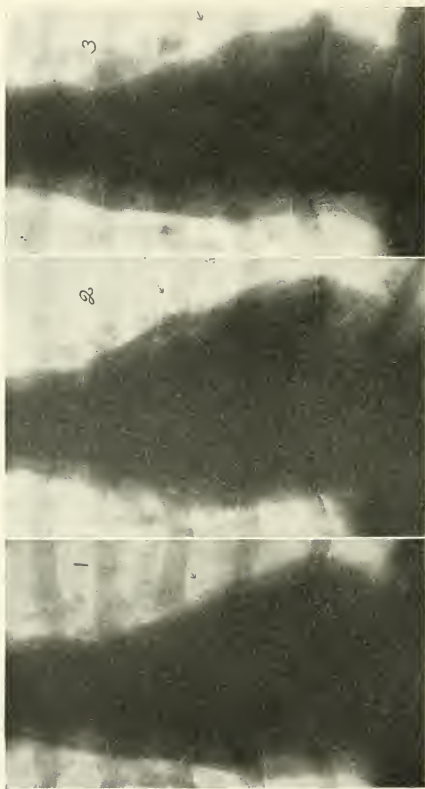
“Seven-foot” roentgenograms taken in Case 4 (paroxysmal auricular tachycardia; mitral stenosis) (1) November 6 before; (2) November 7 during, and (3) November 10 after the attack. Arrow points to left auricle. Note prominence of auricular shadow during attack. No appreciable increase in transverse diameter of heart shadow.
